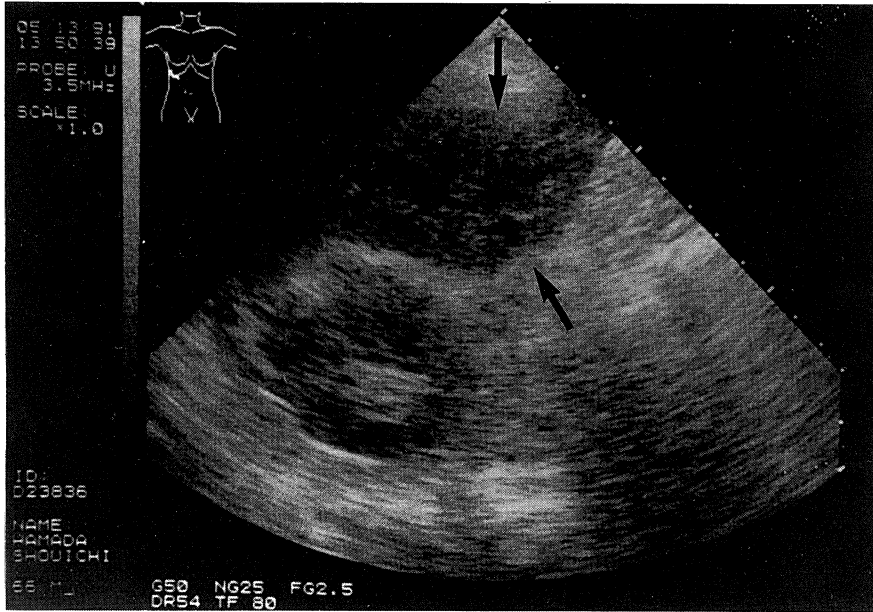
Ultrasonography of the liver demonstrates a hypoechoic mass.
